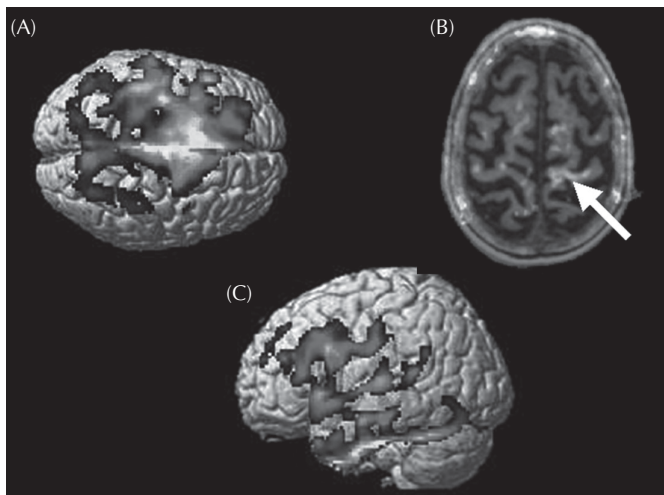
Ligand PET studies can reveal mechanisms in MND. Areas of reduced binding of flumazenil over the motor and association cortices (shown on generic 3D brain from above, A) support neurophysiological evidence of increased cortical excitability in ALS. Focal uptake of the microglial ligand PK11195 (shown on axial MRI image, B) was seen in the left motor cortex (arrow) of an MND patient with right hemiparesis. Markedly reduced frontotemporal binding of the 5-HT1A receptor ligand WAY100635 was noted in non-depressed MND patients (shown on generic 3D brain seen from left).
